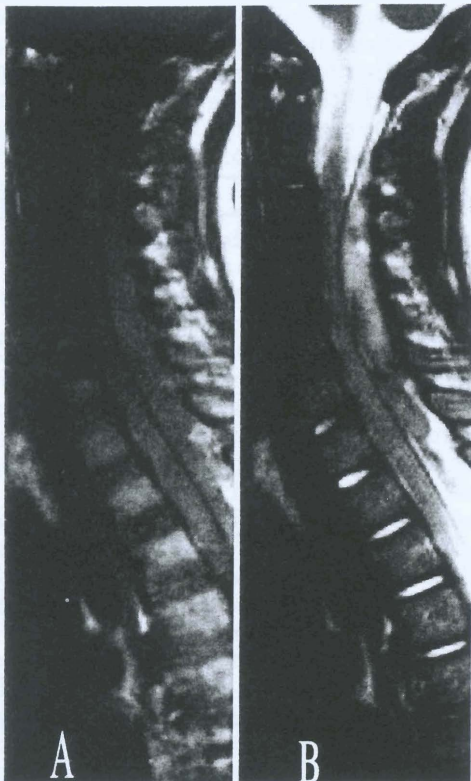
Sagittal MR images obtained in a 2-year-old boy suffering from sudden-onset tonic head turning to the left and rapid sensorimotor paralysis (ASIA Grade A). A: A T₁-weighted image of the cervicothoracic spine revealed an isointense C2–T4 fusiform intraspinal lesion. B: A T₂-weighted image demonstrating that the lesion became primarily hyperintense to the spinal cord with foci of hypointensity. After complete neurological deficits persisted for 8 hours, the patient underwent laminectomy and evacuation of the intraspinal lesion, which was proven to be a fresh blood clot. Recovery was complete within 6 months. The SSEH had not recurred by the 3.5-year follow-up examination.
